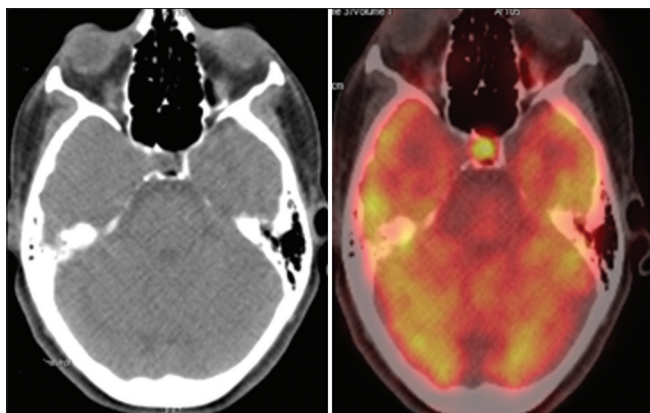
Positron emission tomography/computed tomography axial computed tomography image and axial fusion image showing hypermetabolic foci in the pituitary gland
